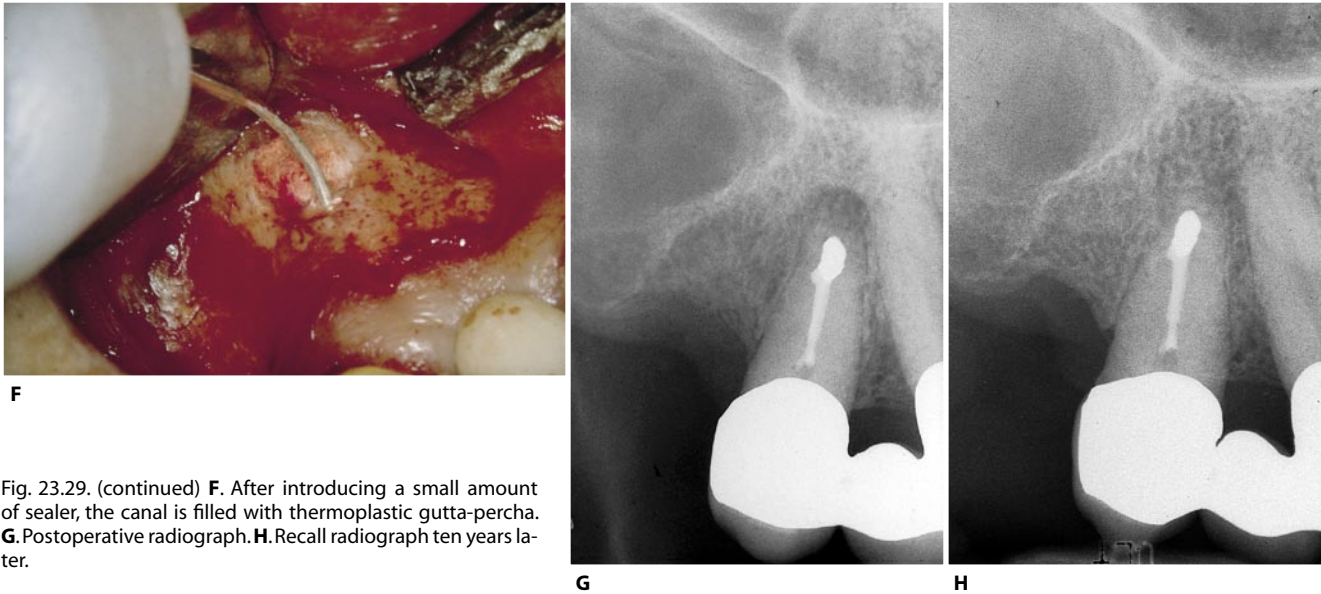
(continued) F. After introducing a small amount of sealer, the canal is filled with thermoplastic gutta-percha. G. Postoperative radiograph. H. Recall radiograph ten years later.
